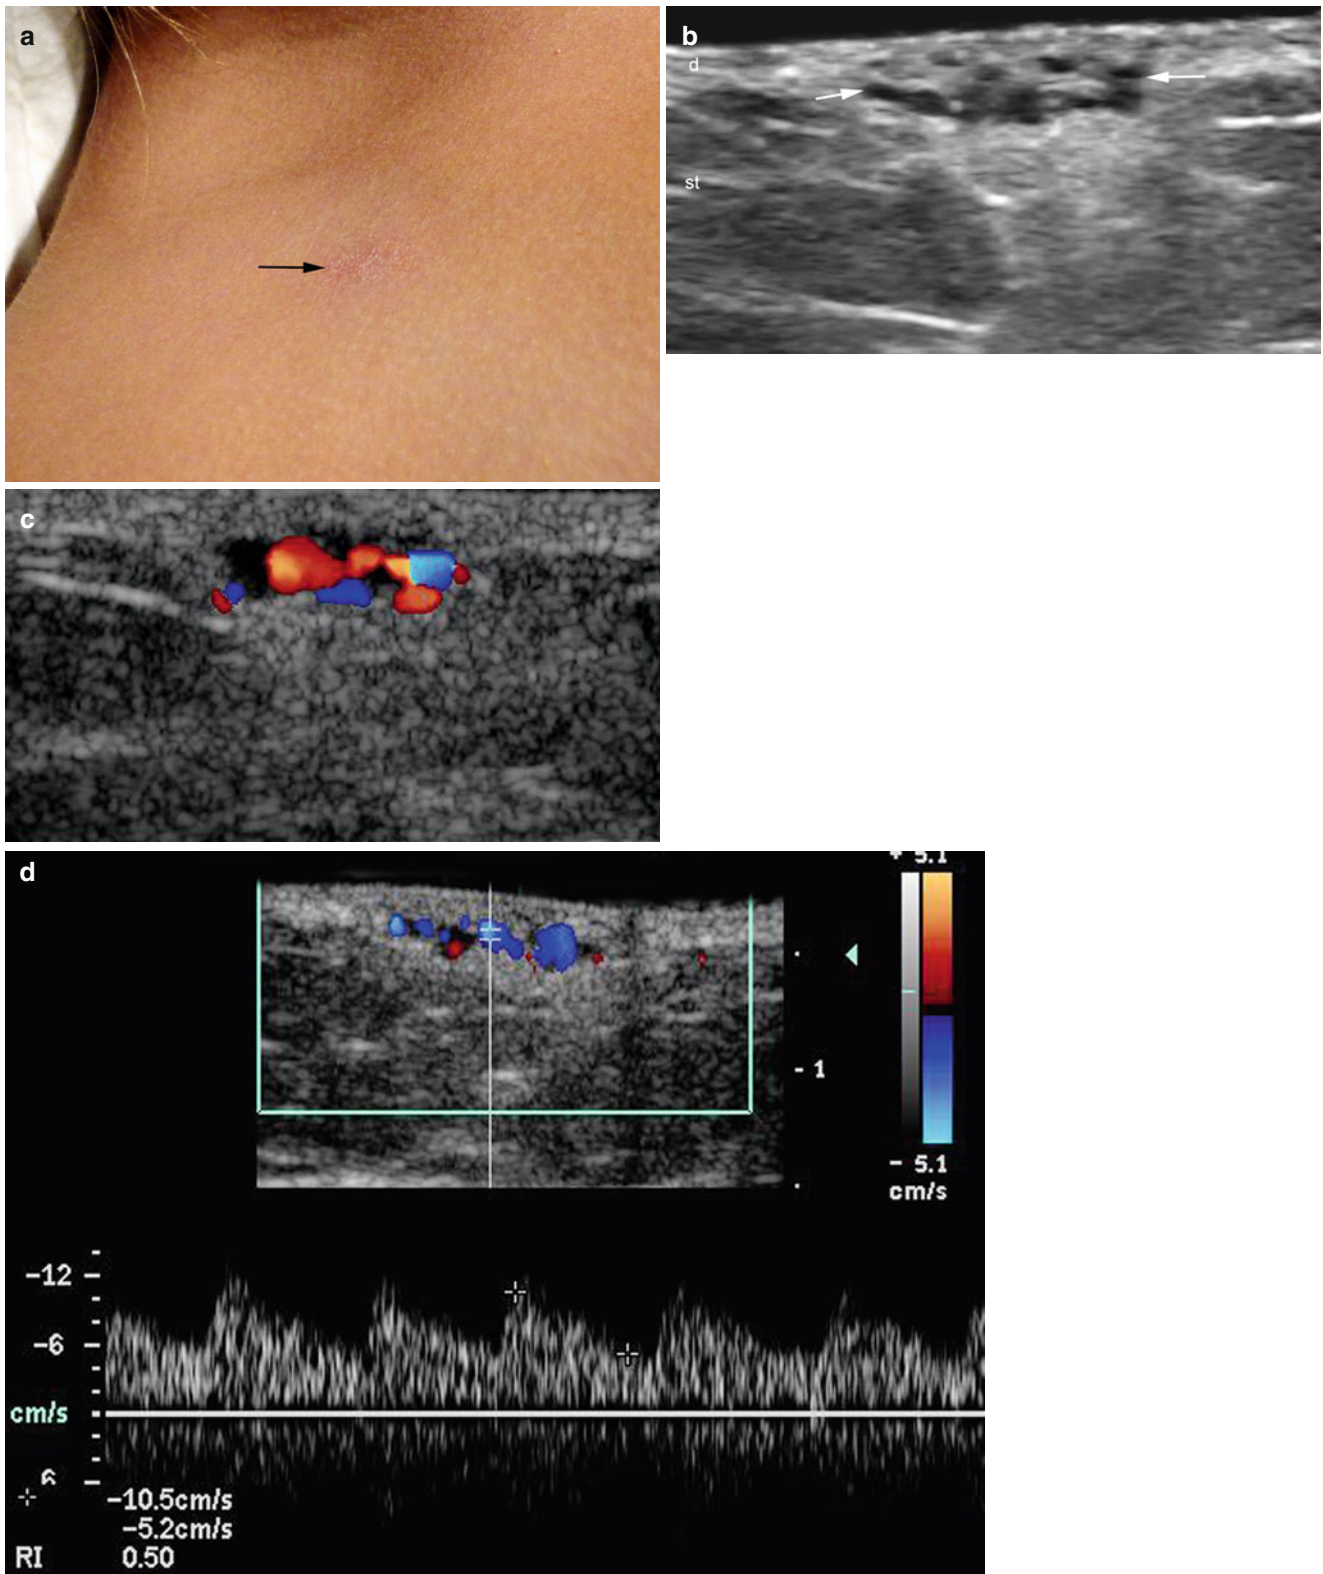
(a–d) High-flow arterial vascular malformation. (a) Clinical erythematous and scaly lesion in the right clavicular region. (b) Grey scale ultrasound image (transverse view) shows multiple anechoic tubules (arrows) in the dermis and subcutaneous tissue. (c) Color
